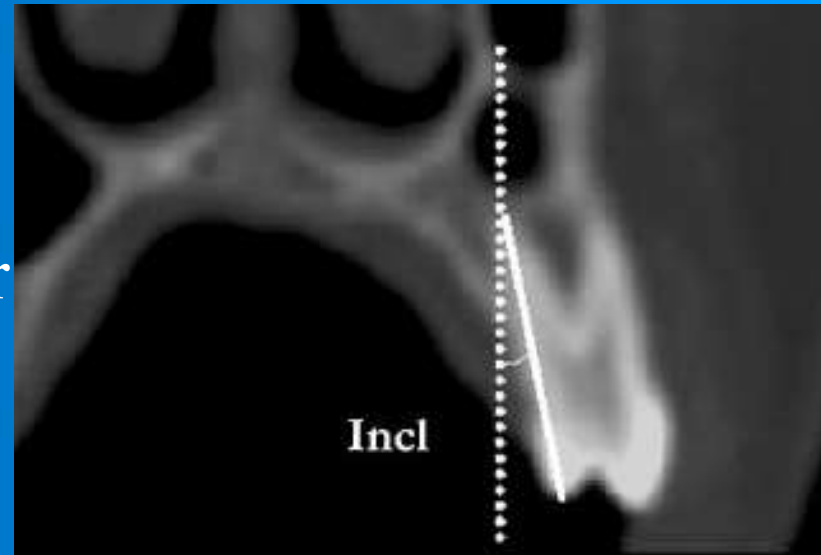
Incl—tooth inclination, corresponding to the angle between one line passing through the palatal cusp tip and palatal root apex, and one line perpendicular to the CT image lower border.
